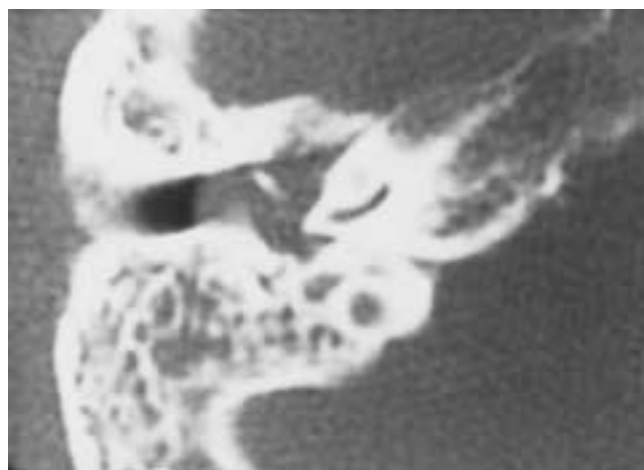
Adenomatous tumor, mixed pattern type. CT. The tumor filling the tympanic cavity and medial EAC, without destruction of the middle ear ossicles, is identical in appearance to the glomus tympanicum tumor. (Compare with Fig. 25-64.) Dynamic contrast CT may help make the differentiation. Because the surgical approach is basically the same for both tumors, angiography for the differential diagnosis is not warranted.
